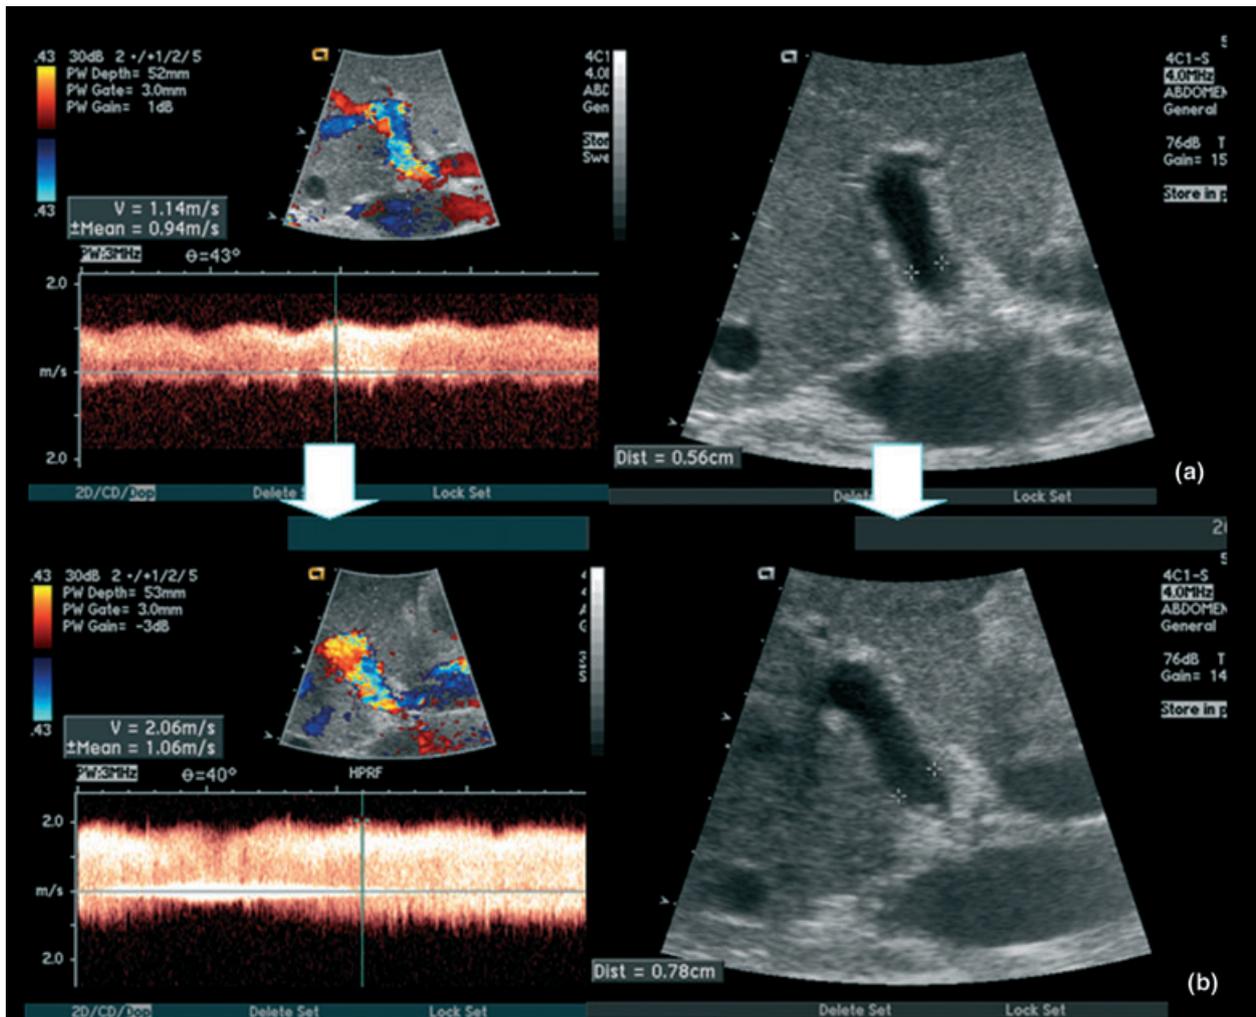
Intra-operative Doppler ultrasonography examination for the effect of left renal vein (LRV) ligation. (a) Doppler ultrasonography displayed portal flow velocity (114 cm/s), portal flow (1560 ml/min), and stenotic main portal vein (PV) (5.6-mm diameter) just after engraftment. (b) The increment of portal flow velocity (206 cm/s), portal flow (2850 ml/min), and stenotic main PV (7.8-mm diameter) was noted after LRV ligation.
